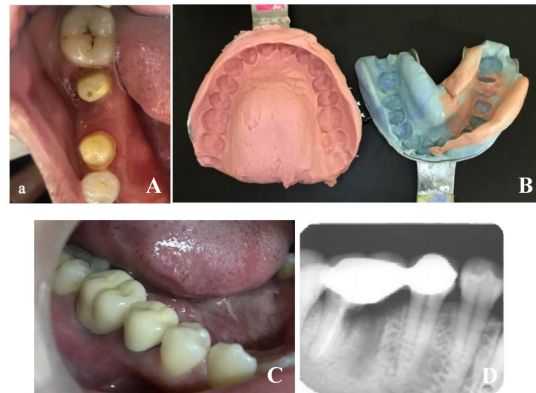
A. Preparation results, B. Results of printing the maxilla and mandible, C. Crown splinter insertion, D. Radiograph after post insertion
